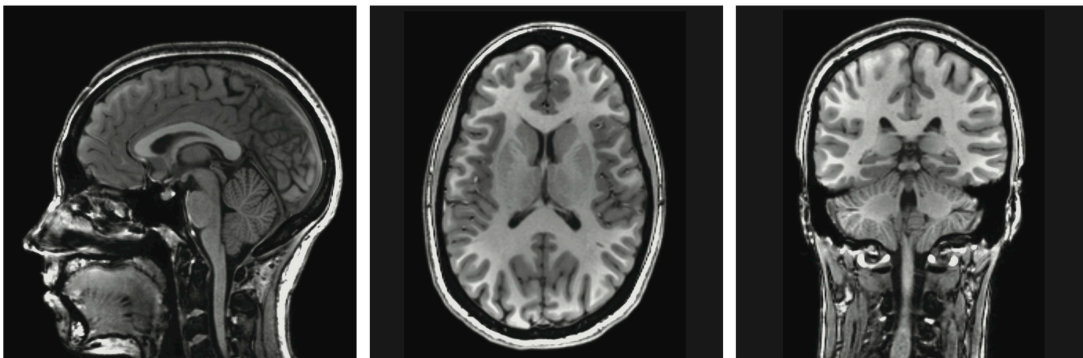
Structural MRI of a healthy young adult subject. Sagittal, axial, and coronal slices from a structural T_1 scan of a healthy subject. Images taken from MRI scan of author.
